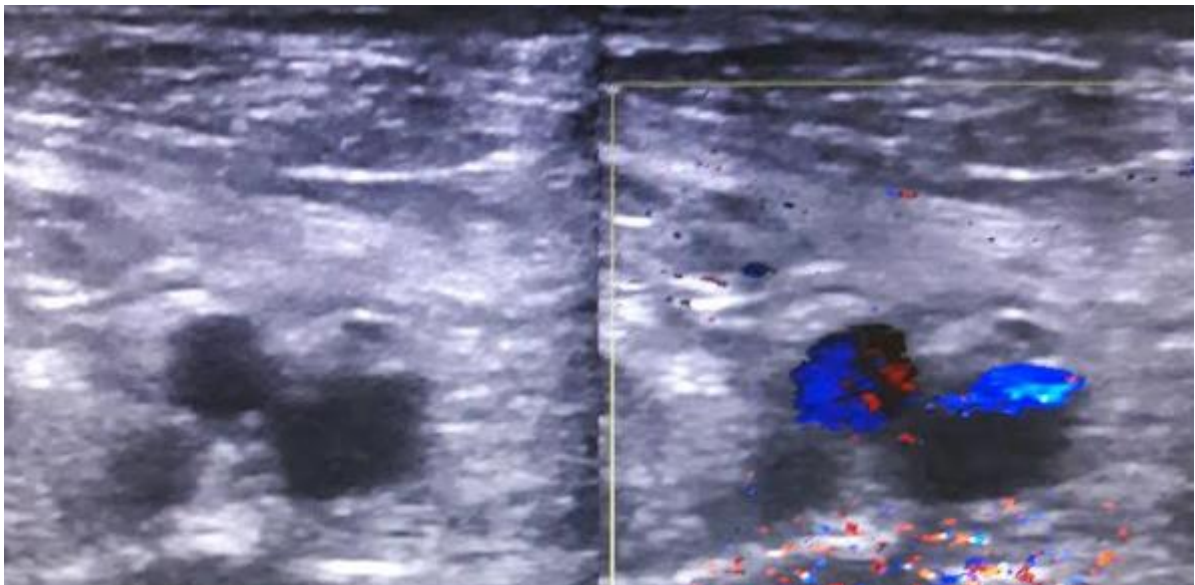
Axial images on grey and color Doppler showing thrombosis of superficial and deep femoral vein thrombosis.
